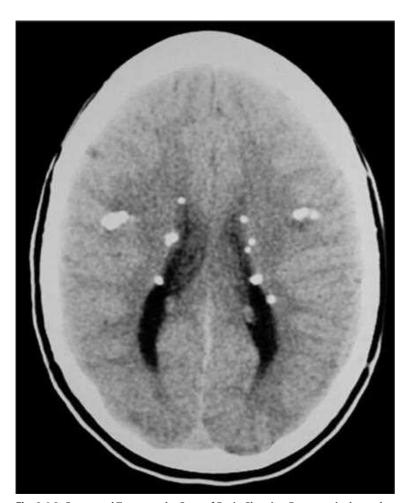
Computed Tomography Scan of Brain Showing Paraventricular and Intracerebral Astrocytomas in a Patient With Tuberous Sclerosis.
